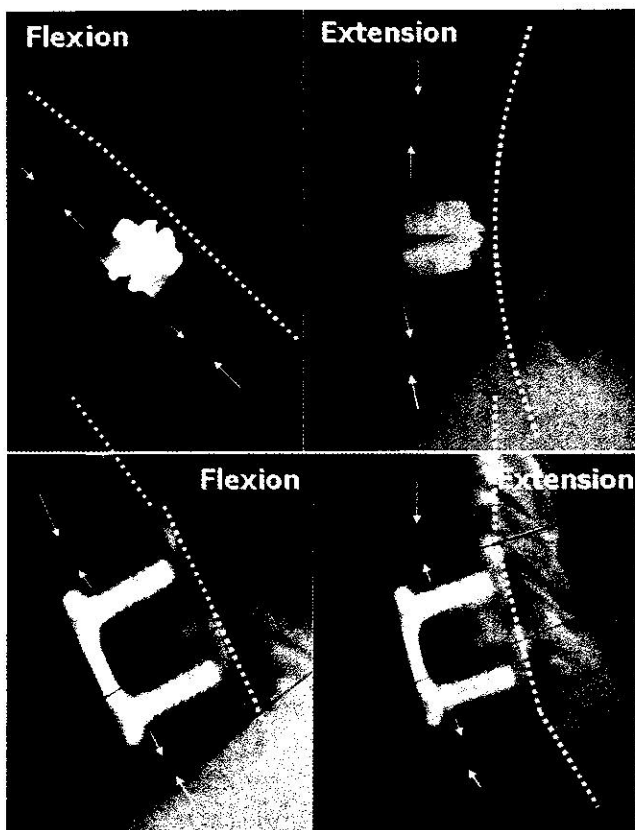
Top: Flexion-extension radiographs after cervical disc arthroplasty reveals relatively normal range of motion of adjacent segments, with the posterior vertebral edges forming a smooth curve. Below: Flexion-extension radiographs after cervical fusion reveal hypermobility at the adjacent segments, with sharper angulation of posterior vertebral edges, and in this case, even some anterior translation.
